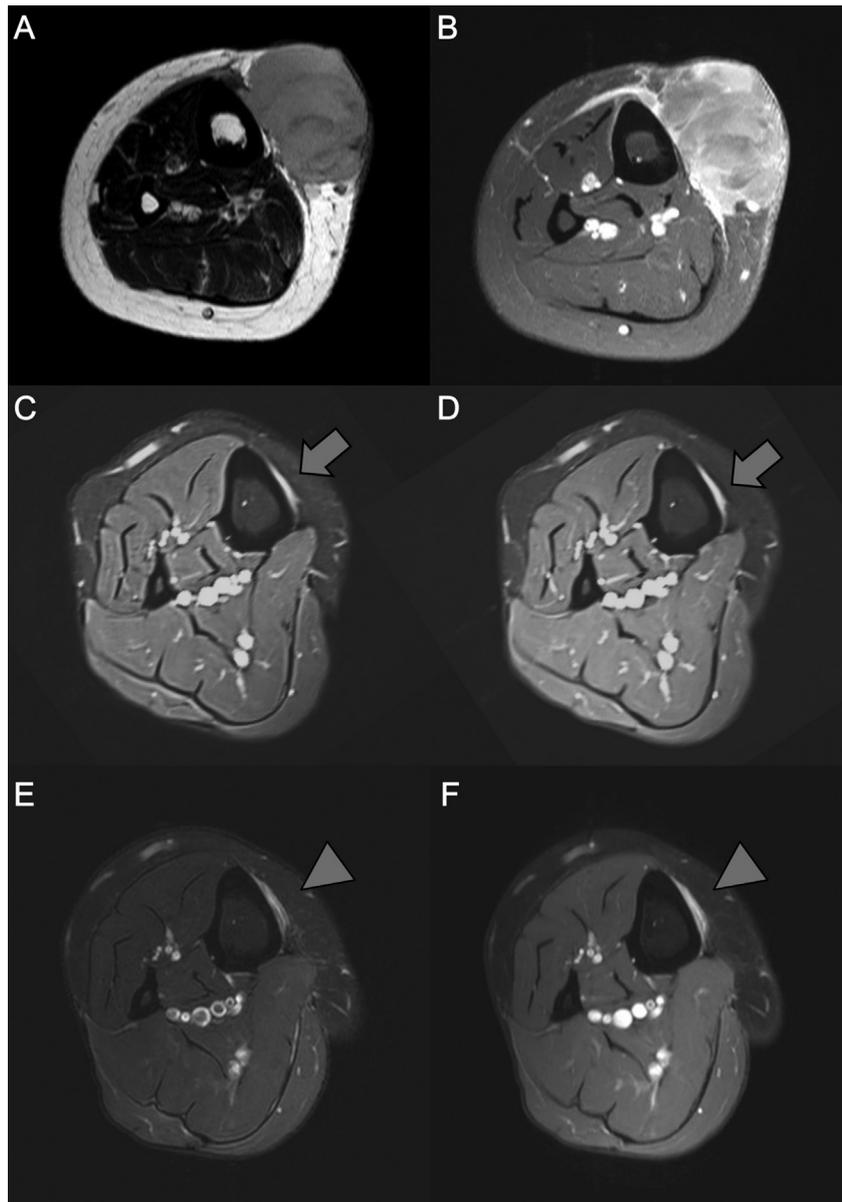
Representative case of MRI-detected local recurrence. A 44-year-old woman with undifferentiated pleomorphic sarcoma in the pretibial area was diagnosed of local recurrence with non-mass forming morphology. A and B, Preoperative axial MRI shows a large soft tissue mass in the pretibial area with deep fascial thickening adjacent to the main mass. The soft tissue defect was reconstructed with a sural fasciocutaneous flap. C and D, At postoperative 32 months, thick curvilinear T2 hyper-intense lesion was observed (arrows). E and F, On follow-up MRI 3 month later, the lesion became thicker (arrowheads) and was confirmed as local recurrence by biopsy. A, C, E: T2-weighted images, B, D, F: Gadolinium-enhanced T1-weighted images.
